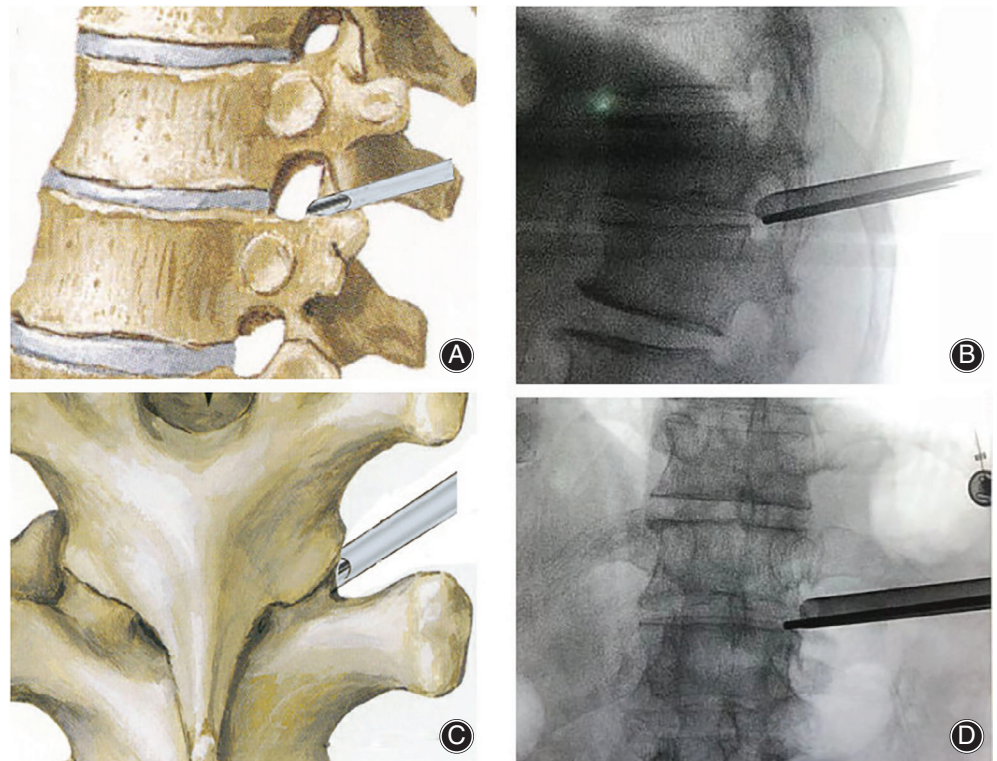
The working sleeve landed on the superior articular process. (A) Lateral view of working sleeve location and (C) dorsal view of working sleeve location. (B) and (D) Sagittal and coronal view, respectively, of working sleeve under X-ray fluoroscopy.
